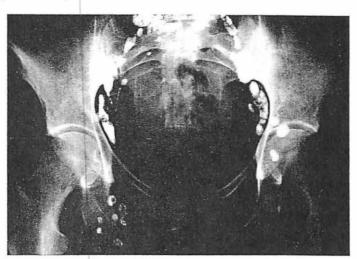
a Lymphography with Lipiodol UF - anteroposterior radiograph of pelvis 36 hrs after injection shows almost total evacuation of the lymphatic channels.
